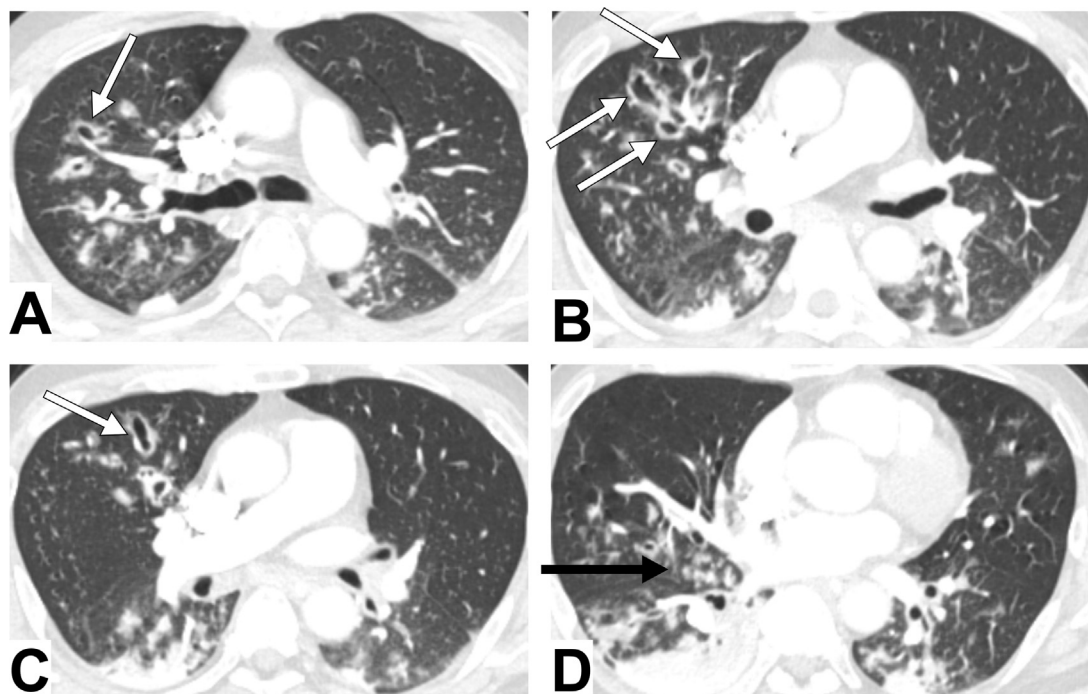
Chest computed tomography (CT) on hospital day 5 (A–D). Chest CT shows consolidation with bronchiectatic cavity formation (white arrow) and centrilobular nodules (black arrow).
